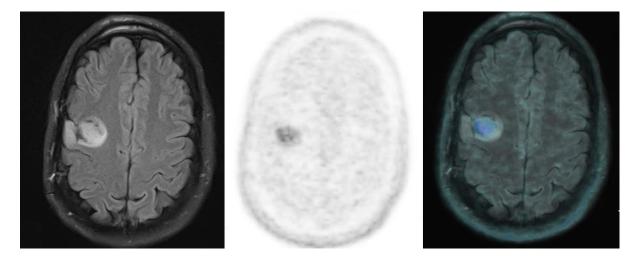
Left to right: axial flair MRI, 18F-dihydroxyphenylalanine (F-DOPA) PET, and fused PET/MRI in a patient with previously de-bulked glioma in the right frontal lobe showing focal F-DOPA uptake indicating recurrent tumour.
